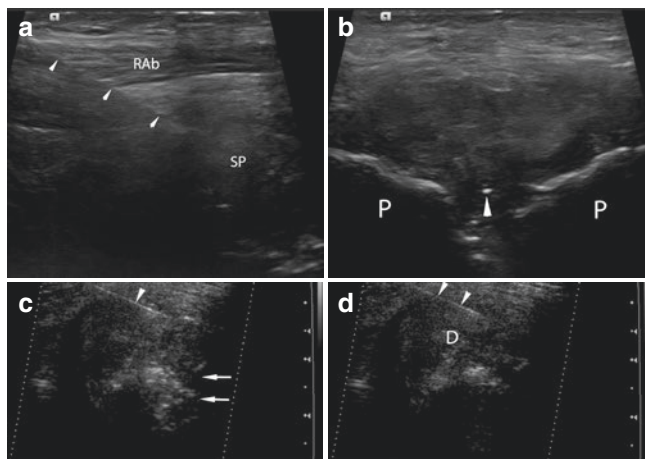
(a) Longitudinal ultrasound image shows the needle (*arrowheads*) passing from superior end to the probe, through the rectus abdominis (Rab) in the joint (SP). (b) Transverse ultrasound image shows the needle tip (*arrowhead*) in the joint between the pubic bodies (P). (c) Angled ultrasound image shows the needle and echogenic disc (D) before injecting. (d) After injection echogenic injectate flows away (*arrows*) from the needle tip (*arrowhead*)
